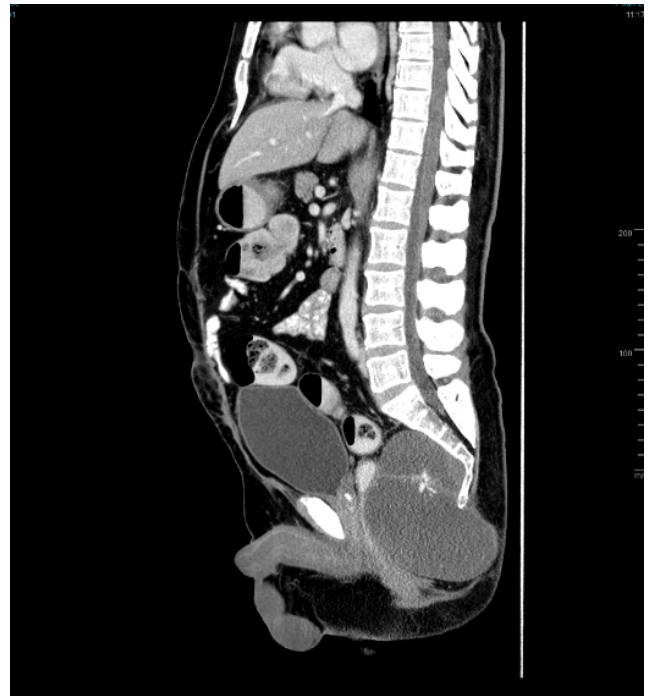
CT ABDOMEN. presacral mass.Se106.Img1
